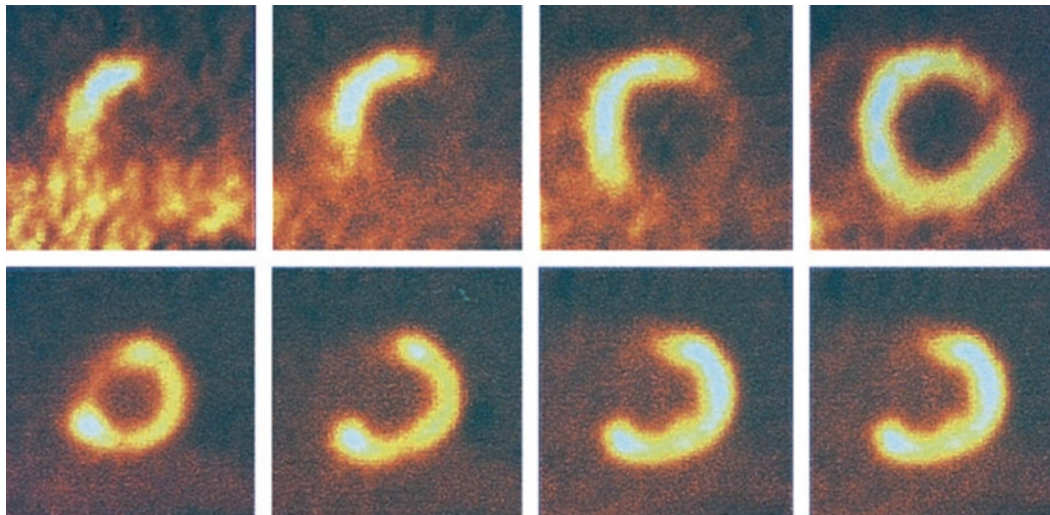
PET scans demonstrating perfusion-metabolism mismatch (reduced blood flow with preserved or enhanced FDG uptake) in a patient with chronic ischemic left ventricular dysfunction and heart failure symptoms. The principle of using a metabolic tracer, such as FDG, is based on the concept that viable myocytes in hypoperfused and dysfunctional regions are metabolically active, whereas scarred or fibrotic tissue is metabolically inactive. Although fatty acids are the primary source of myocardial energy production in the fasting state, in the setting of reduced oxygen supply (a consequence of hypoperfusion at rest), the myocytes compensate for the loss of oxidative potential by shifting toward greater glucose utilization to generate high-energy phosphates. Thus, in chronic ischemia, aerobic metabolism is slowed
